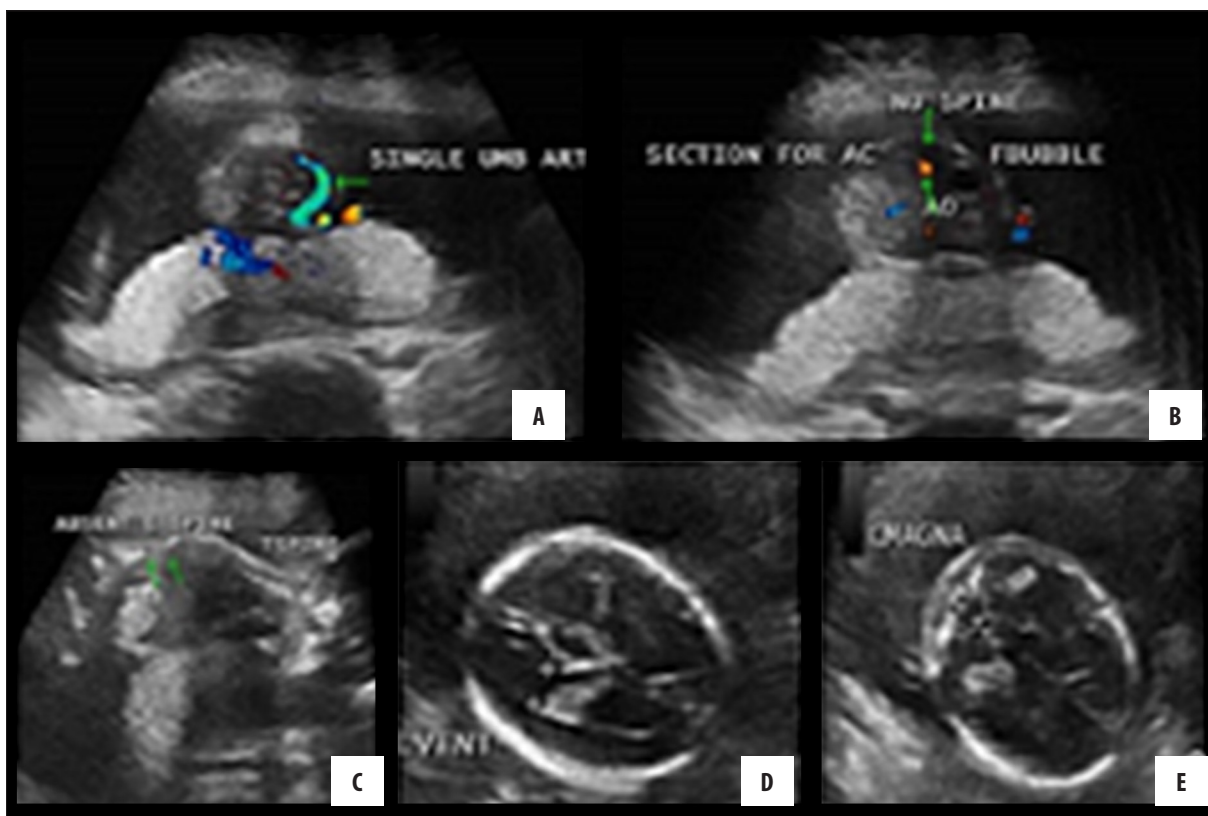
Doppler ultrasound images: (A) Axial section of the foetus showing single umbilical artery. (B) Axial section of the abdomen at the level of fundic bubble showing absence of the spine. (C) Sagittal section of the foetus showing absence of the lumbar and sacral spine. (D, E) Axial sections of the foetus showing normal left ventricle measuring 7.6 mm and normal cisterna magna measuring 5.5 mm.
